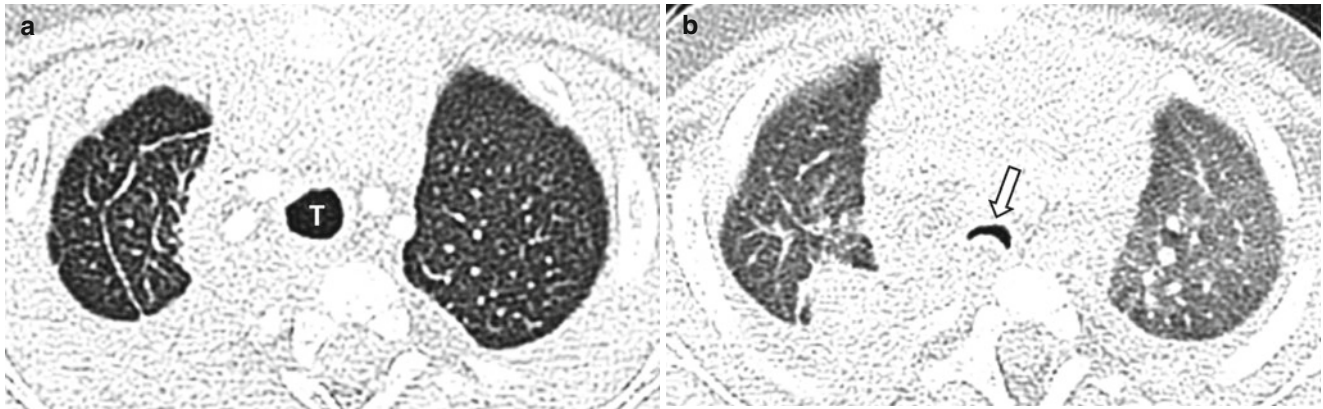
Tracheomalacia in a 17-month-old boy with a history of prematurity who presented with recurrent severe respiratory distress and apnea. (a) Axial CT lung window image obtained at end-inspiration shows patent trachea (T). (b) Axial CT lung window image obtained at
